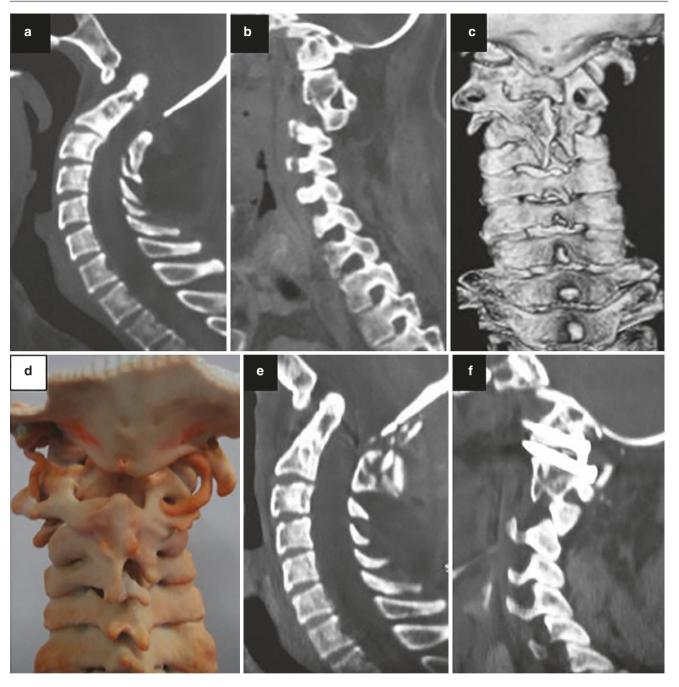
Imaging findings in a 32-year-old man. Preoperative computed tomography (CT) shows basilar invagination and assimilation of the atlas (a) and facet alignment (b). Three-dimensional (3D) reconstructed CT (c) demonstrates assimilation of the atlas and the location of foramen transversarium on both sides (note the thin pedicle on the right
